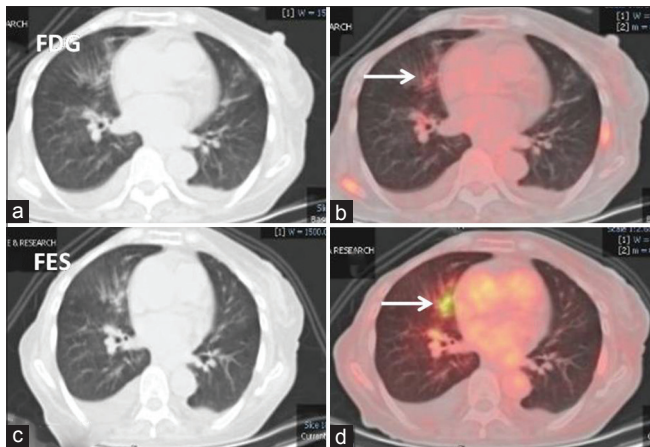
Lung window computed tomography and fused ¹⁸F-fluorodeoxyglucose (a and b) and ¹⁸F-fluoroestradiol (c and d) positron emission tomography-computed tomography axial images: ¹⁸F-fluorodeoxyglucose avid prominent bronchial markings with peribronchial infiltrates in the right middle lobe which shows good ¹⁸F-fluoroestradiol uptake (white arrows). Findings favor lymphangitis carcinomatosa
